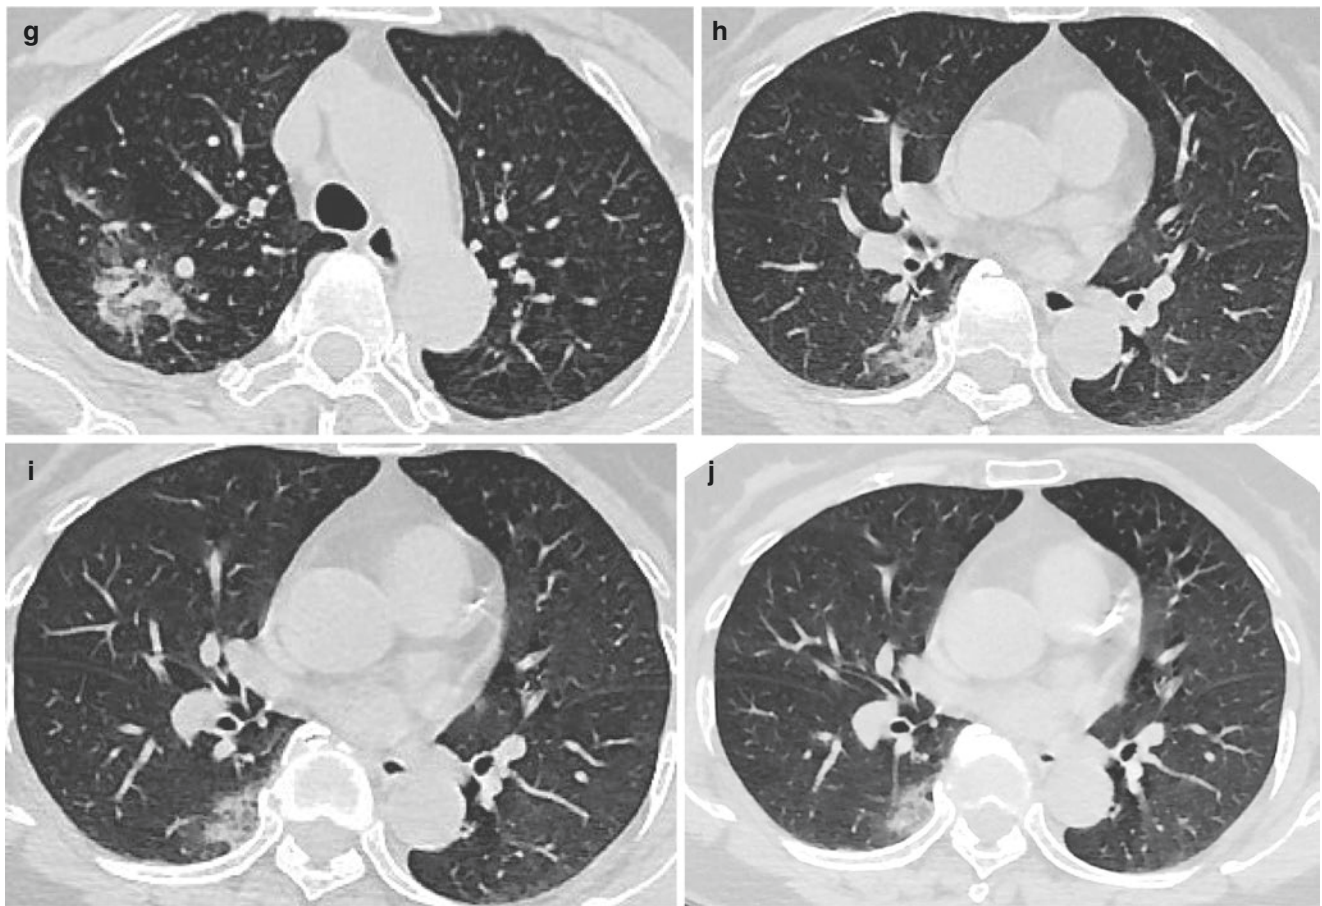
CT images showed a segmental consolidation in the posterior segment of the upper lobe of the right lung with “air bronchogram” (c–g). There was a small patchy increase in the density of the basal segment of the right lower lobe (h–j)
